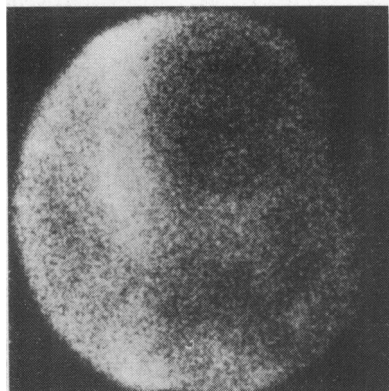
A ^{99m}Tc -PYP scintigram obtained in a patient with an acute subendocardial myocardial infarction. Note the characteristic faint and diffuse uptake of the ^{99m}Tc -PYP in this type of infarction.
